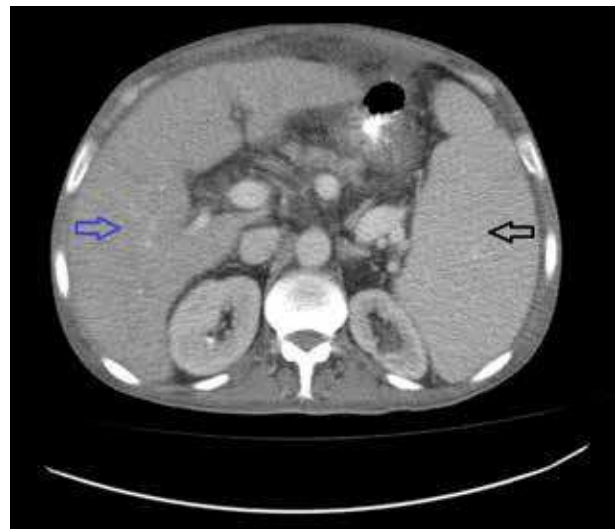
CT screening of the patient. Cirrhotic liver (blue arrow) and splenomegaly (black arrow).
